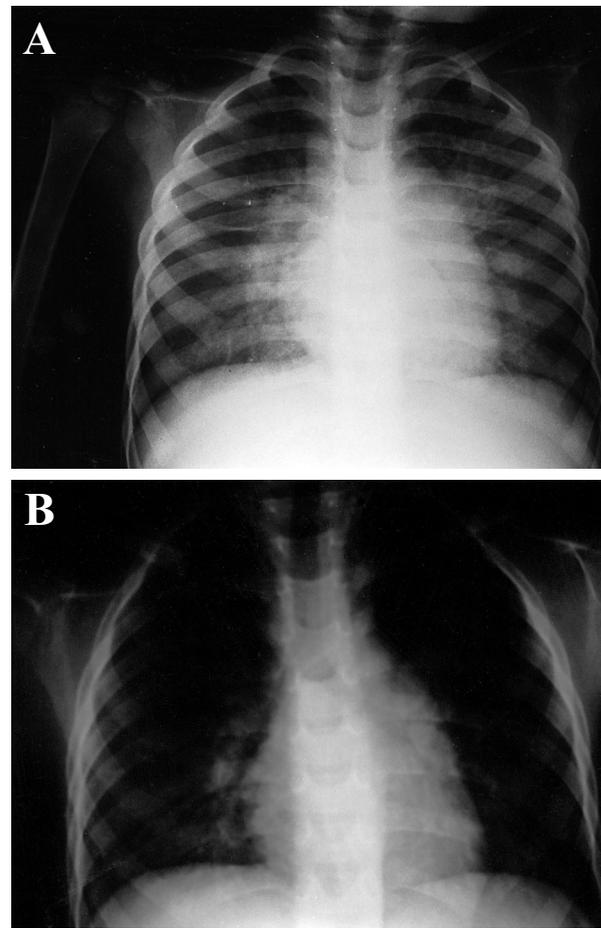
(A) Chest X-ray shows increased infiltration with perihilar haziness over bilateral lung fields. (B) After treatment with IVIG and 5 days of TMP-SMZ therapy, the chest plain film reveals resolution of the interstitial pattern.
